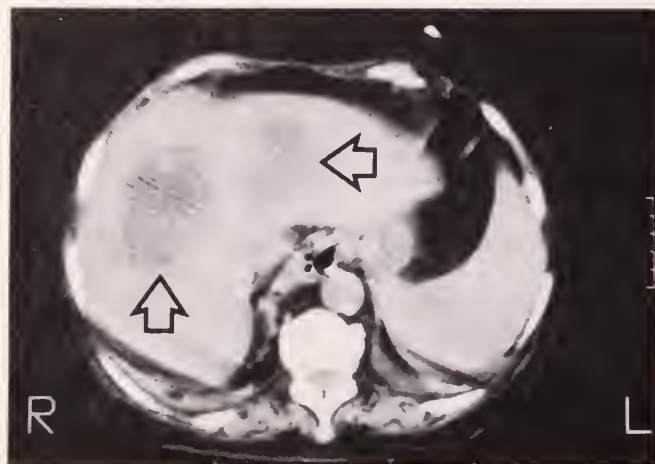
a & b: It would have been helpful if these “kissing” hepatic abscesses had communicated, but alas, they did not. Drained on sequential days after a CT Scan revealed only one emptied. Premedicated for bacteremia she still had a stormy four hours post-drainage.
